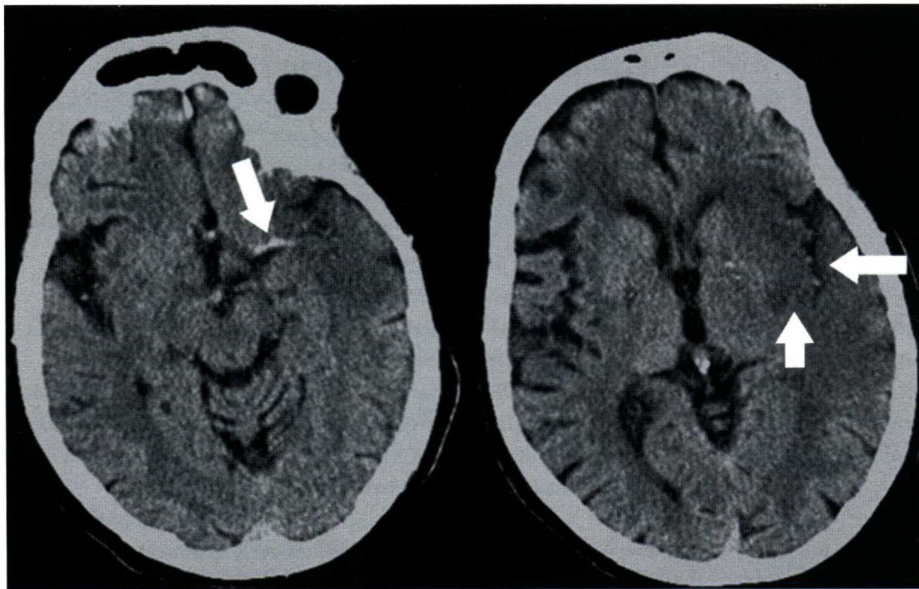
Axial CT images show increased attenuation associated with the left MCA and its branches (arrows) compatible with thrombosis. Decreased gray/white differentiation in the left insular ribbon and putamen (short arrow) is compatible with acute infarct.
